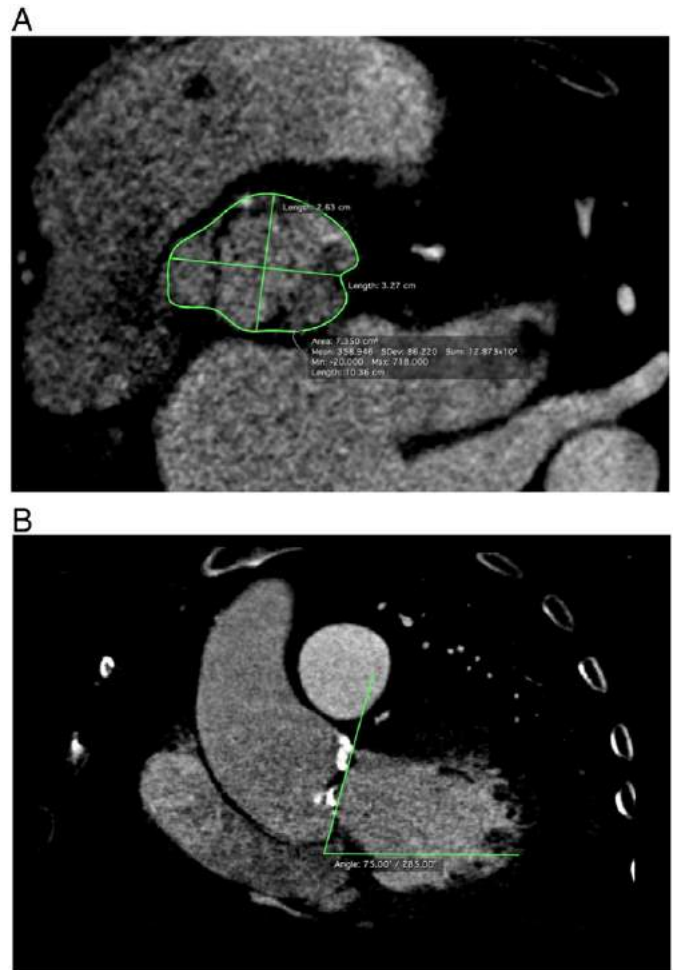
A. The maximum and minimum aortic annulus diameter and annulus area. B. Calcified aortic valve and aortoventricular angle was measured as 75° in coronal plane of multidetector computed tomography.
